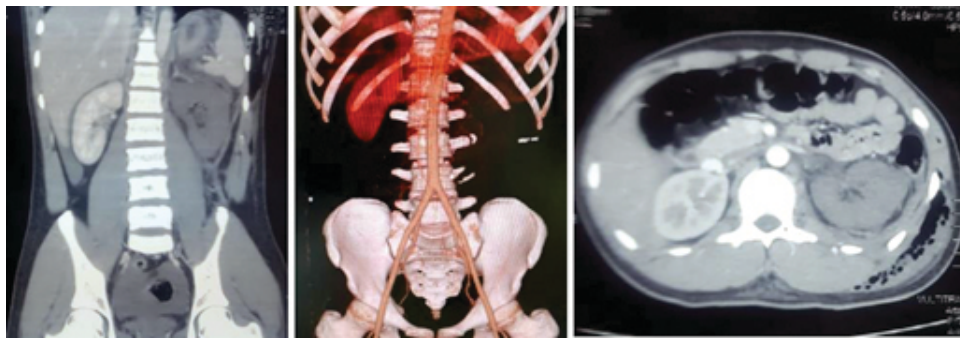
Abdominal CT scan with contrast showed no vascularization to the left kidney accompanied by spleen laceration with intraparenchymal hematoma.
